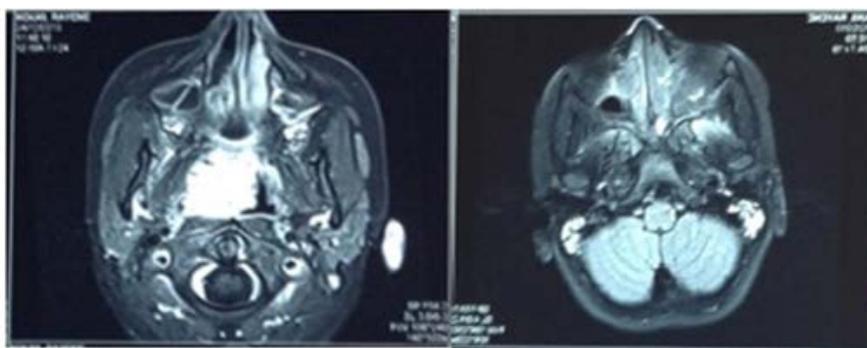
MRI of the Facial Mass Showing the Tumor Developing with Significant Posterior Extension Towards the Nasopharynx.
